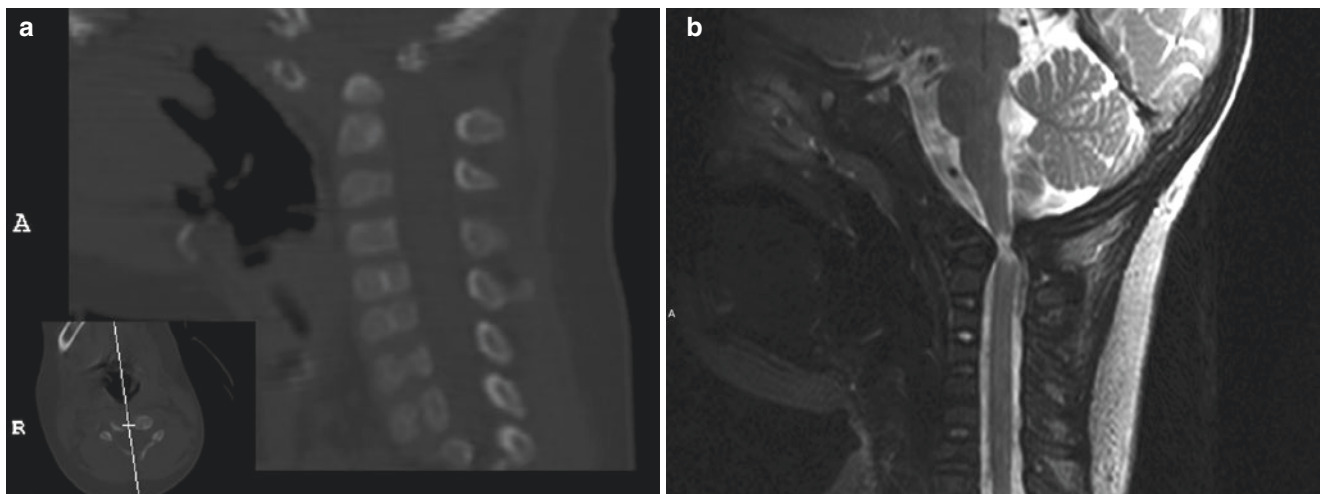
Atlanto axial dislocation. (a) Sagittal reformatted image of cervical spine CT study demonstrates anterior displacement of the C1 arch with respect to the dens. The ADI is increased and the distance between the spinous processes of C1 and C2 is widened. The spinal
